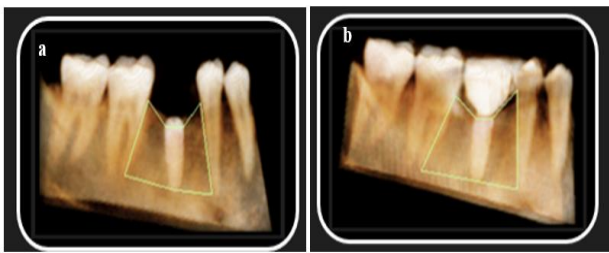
(a) Measuring bone volume around implant at baseline through CBCT, (b) measuring bone volume around implant at 9 months of implant placement through CBCT.
